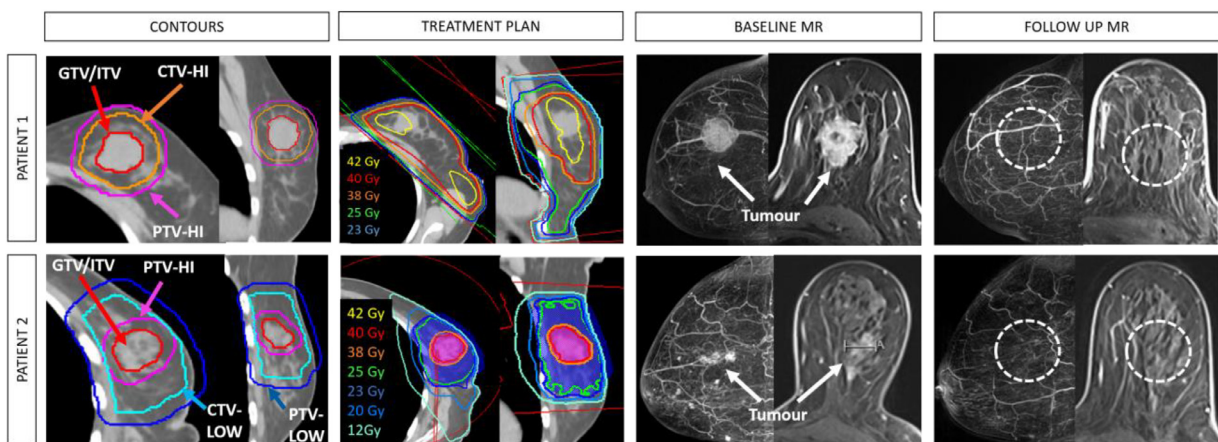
Examples of patients who achieved a complete response after ablative radiation therapy. Patient 1 is a 75-year-old woman with a T2N0M0 triple-negative breast cancer who was deemed not a candidate for surgical resection or systemic therapy because of comorbidities. She was treated with 25 Gy whole breast irradiation and 40 Gy simultaneous integrated boost to the primary tumor in 5 fractions, using 3D-CRT. The patient died of nononcological causes 3 years after radiation therapy, with complete response of the primary tumor and no evidence of distant metastases. Patient 2 is a 94-year-old woman with a T2N0M0 hormone receptor-positive HER2-negative breast cancer who was considered inoperable due to frailty and declined hormone therapy. She was treated with 25 Gy partial breast irradiation and 40 Gy simultaneous integrated boost to the primary tumor in 5 fractions, using volumetric modulated arc therapy. The patient had a complete response and was on surveillance with no evidence of distant metastases 12 months after radiation therapy. *Abbreviations:* CTV-Hi = high-dose clinical target volume; CTV-Low = low-dose clinical target volume; GTV = gross tumor volume; ITV = internal tumor volume; MR = Magnetic resonance imaging; PTV-Hi = high-dose planning target volume; PTV-Low = low-dose planning target volume.
